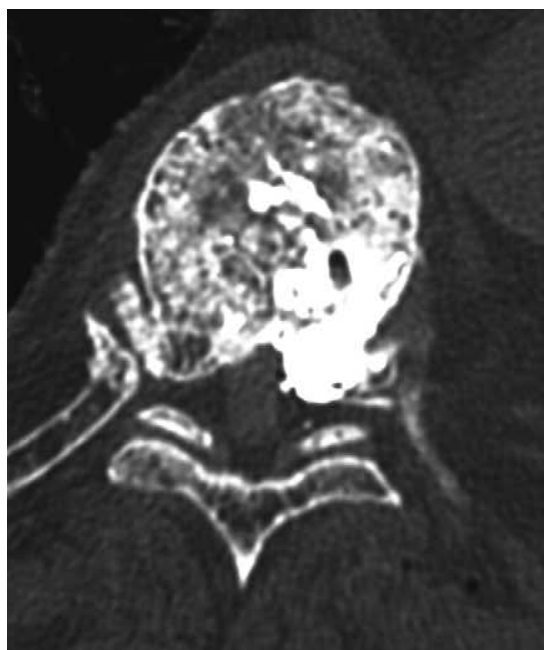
A multiple myeloma vertebral fracture of T7. CT scan control after vertebroplasty showing cement leakage into the epidural space.
